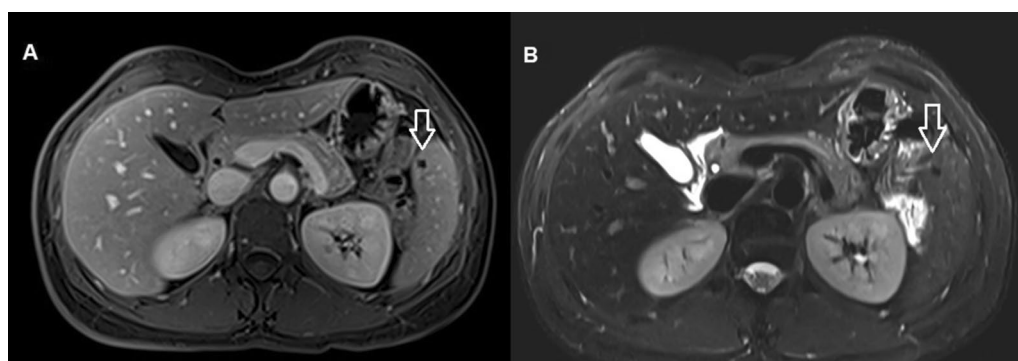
Follow-up MRI shows further shrinkage of the splenic nodule, with preserved benign imaging characteristics, and hypointensity at both axial T1-weighted fat-suppressed post-contrast A and axial T2-weighted fat-suppressed sequences B, likely of nonspecific significance
